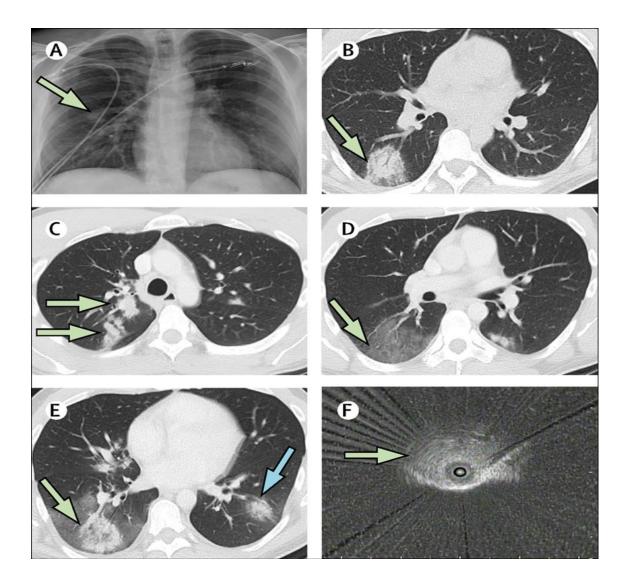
HRCT scan chest (radiologyinfo.org)
